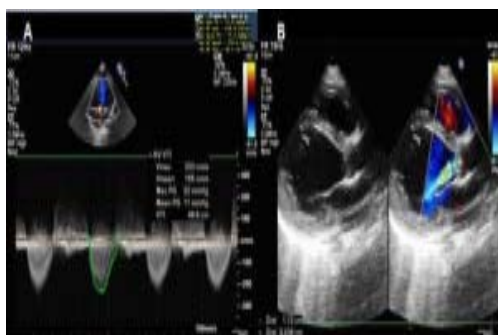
Follow up 2D ECHO at four months showing A) Continuous wave doppler across AV with mean gradient of 11mm Hg. B) Parasternal long axis view showing unrestricted opening of aortic valve leaflets with mild AR.
